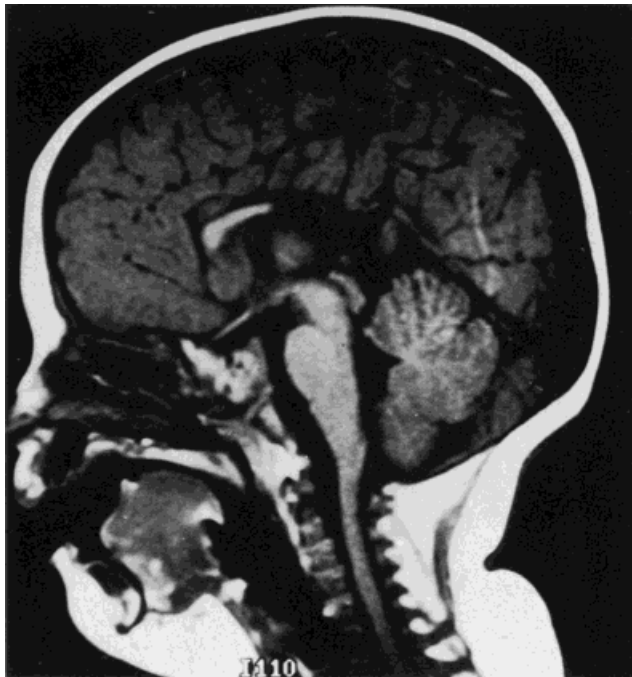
MRI profile of individual IV-3 of family 3 shows absence of the mid and posterior portion of the corpus callosum.
